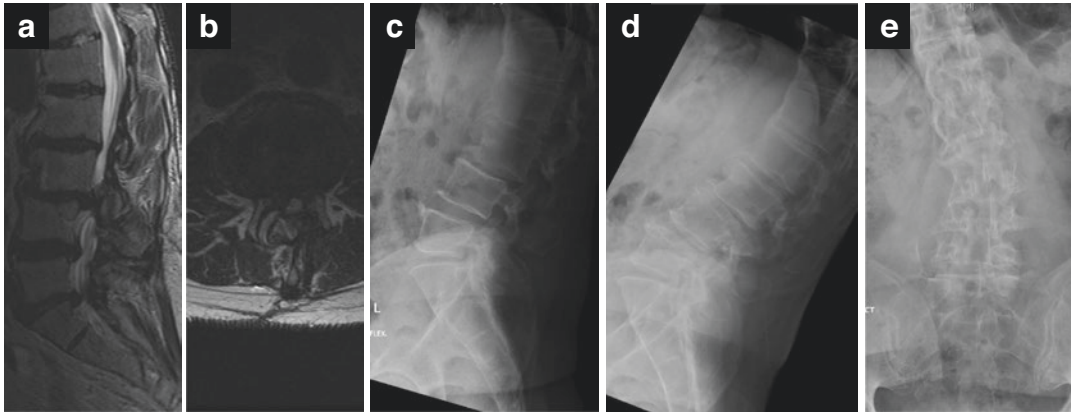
(a) T2-weighted sagittal MRI of the lumbar spine with degenerative changes throughout, most severely involving L3–S1 with significant disc protrusions worst at L3–4 and L5–S1 causing significant lumbar stenosis. (b) Axial MRI at L3–4 with facet gapping and evidence of a disc herniation causing severe canal and lateral
